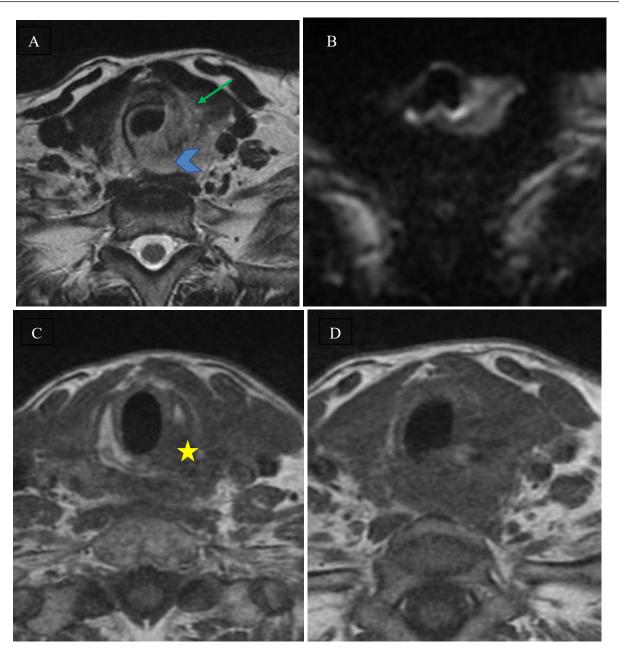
Axial slices of a cervical MRI with T2-weighted imaging in A, diffusion-weighted imaging in B, T1-weighted unenhanced imaging in C and D, and T1-weighted imaging with fat saturation and Gadolinium injection in E and F.
